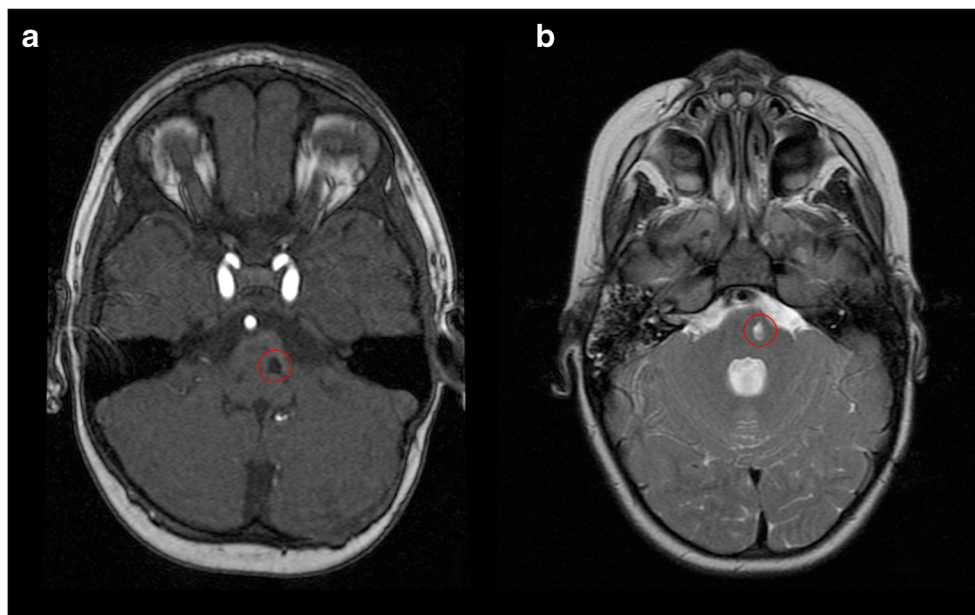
Preoperative axial T2-weighted GRE (Gradient echo) (a) and coronal T2-weighted FLAIR (fluid-attenuated inversion recovery) (b) MRI scans of case 1, showing a hypointense pontine mass (red circle), denoting the ruptured cavernoma and surrounding edema. Postoperative
